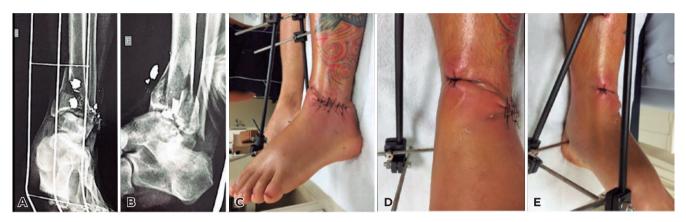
Patient admission. A and B) Radiographic images of the ankle in anteroposterior and lateral views taken upon admission to another hospital. C-E) Photographic images of the patient's leg on admission to our institution showing external fixation and local hyperemia.
